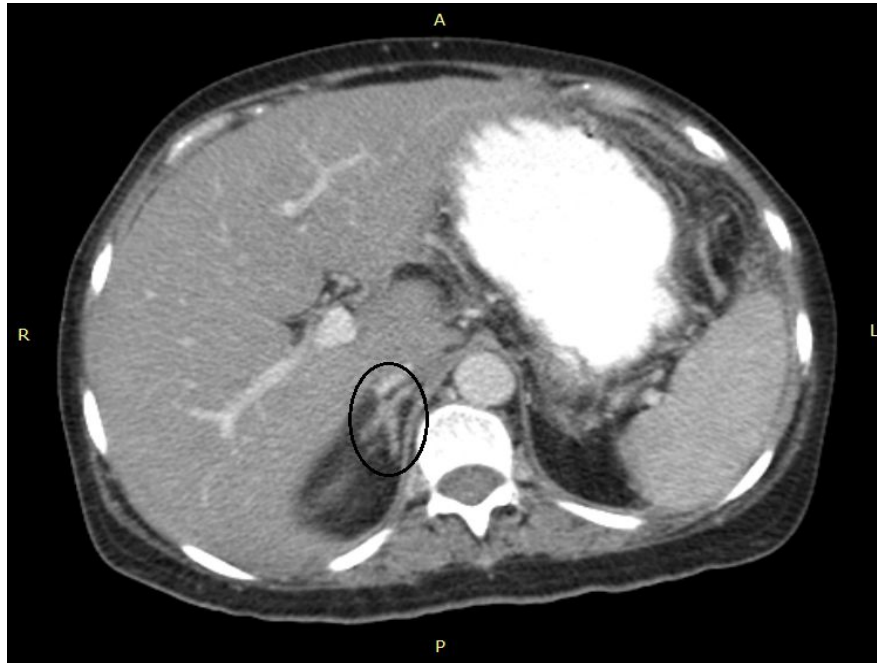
Axial CT image for Female (32 years) shows right adrenal gland (V shape).
